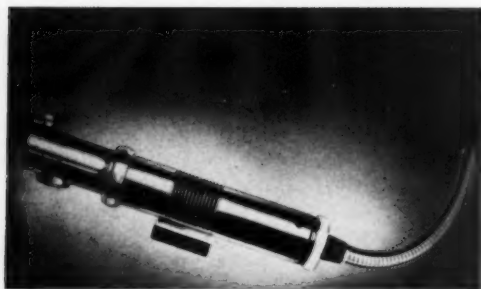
Shock-proof tube with beryllium window; 40-degree x-ray beam. (Courtesy Machlett Laboratories, Inc.)
